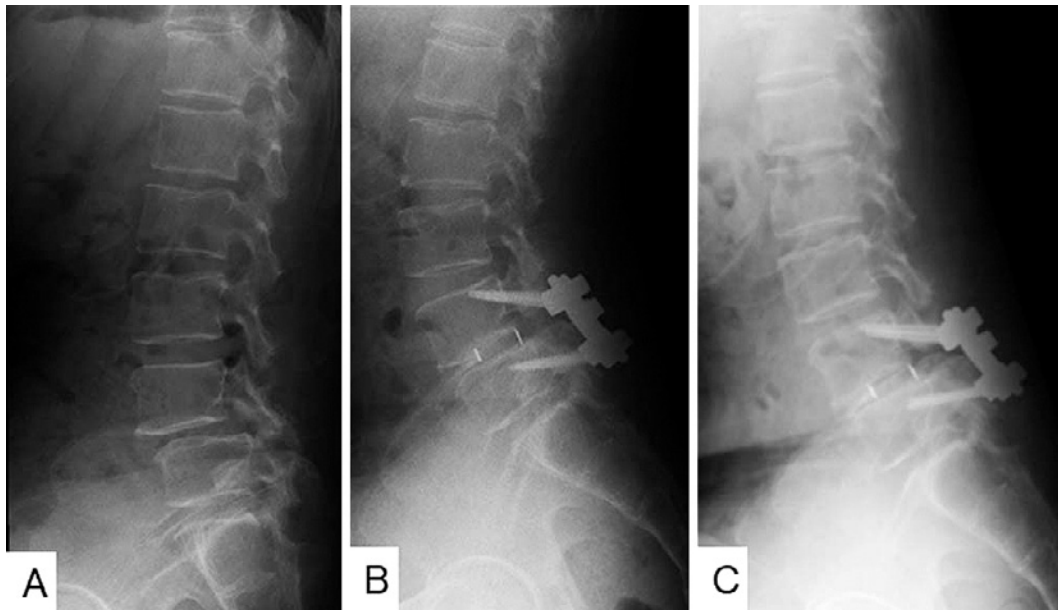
A 62-year-old male patient with symptomatic adjacent segment disease. Standard lateral lumbar radiograph before the initial surgery (A), after the initial surgery (B), and before the second surgery (C).
